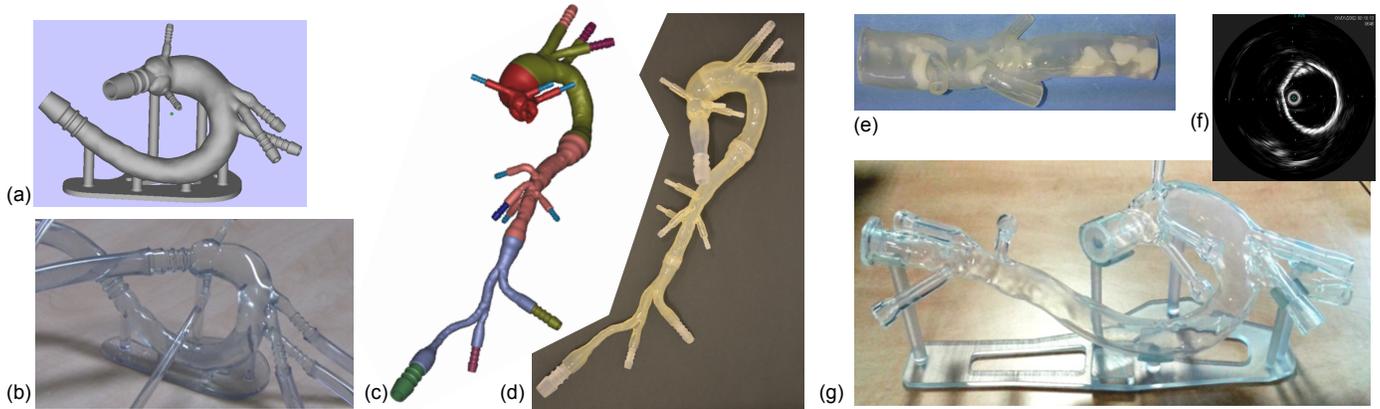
3D printed testbeds - (a)/(b) CAD and printed rigid SLA model; (c)/(d) CAD and printed HeartPrint™Flex model; (e)/(f) multimaterial inkjet 3D model from HeartPrint™ and IntraVascular UltraSound (IVUS) image. Calcifications visible in (e) appear clear in corresponding IVUS image (f); (g) New hybrid silicon casted model showing good transparency and flexibility.
